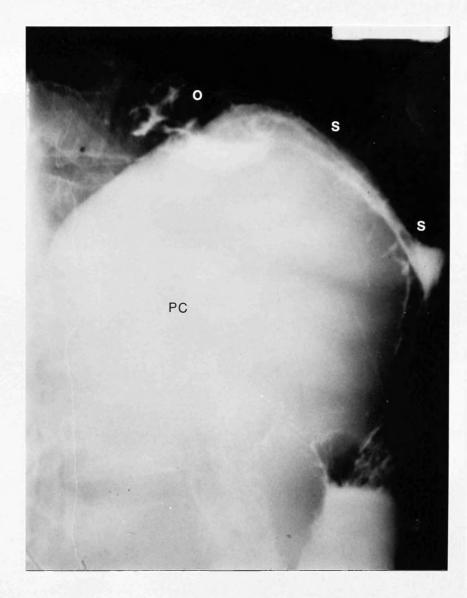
Radiograph of a lateral erect view of a barium meal in a patient with a large pseudocyst.
